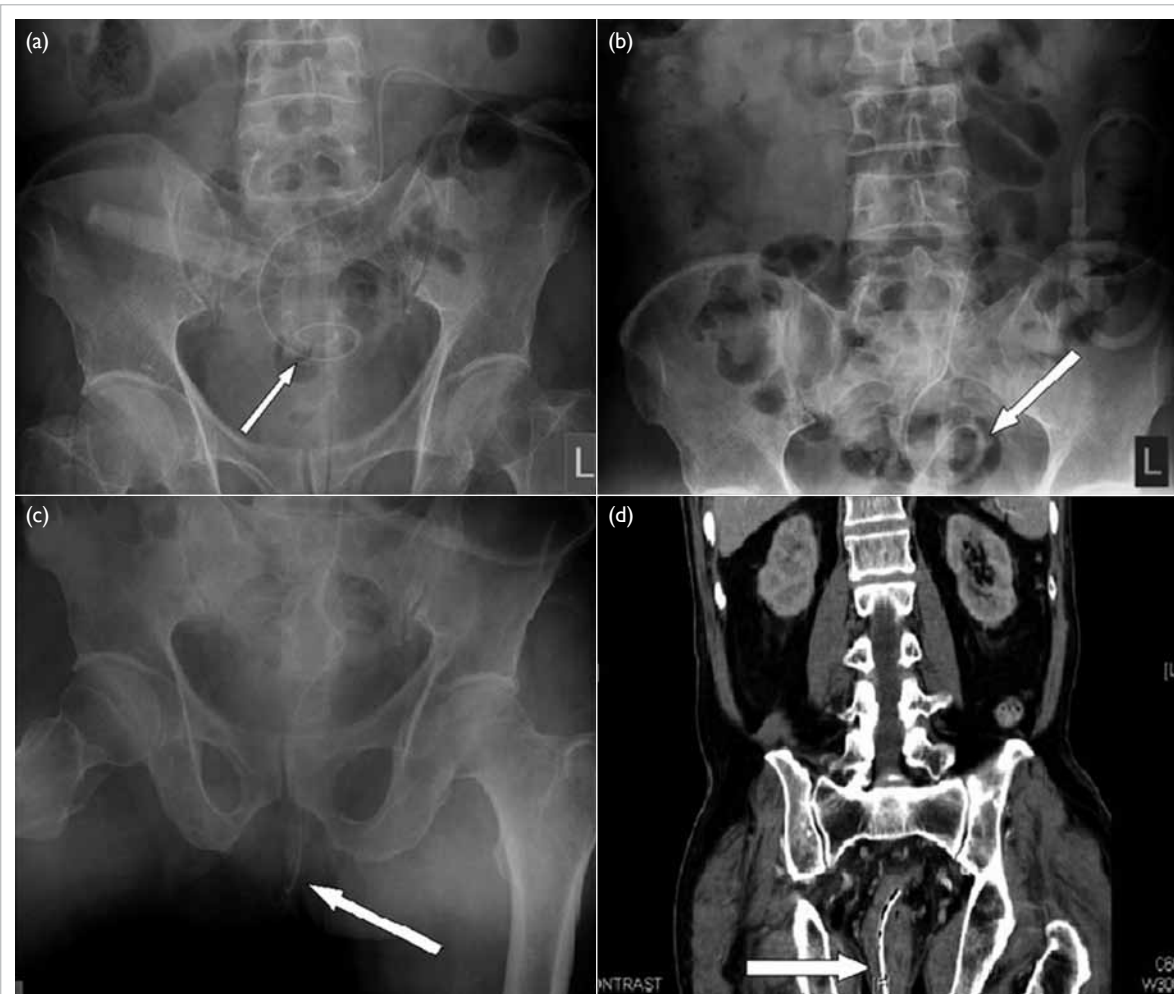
(a) Initial kidney, ureter, bladder X-ray showing the Tenckhoff catheter in the central pelvic cavity (arrow), with coiling of catheter tip; (b) abdominal X-ray 5 months after insertion demonstrating inferior migration of the catheter tip with loss of tip coiling (arrow); (c) pelvic X-ray a few days after (b) showing the Tenckhoff catheter passing out through anus (arrow); (d) contrast-enhanced computed tomography of abdomen and pelvis showing Tenckhoff catheter perforation through the sigmoid colon (arrow)
